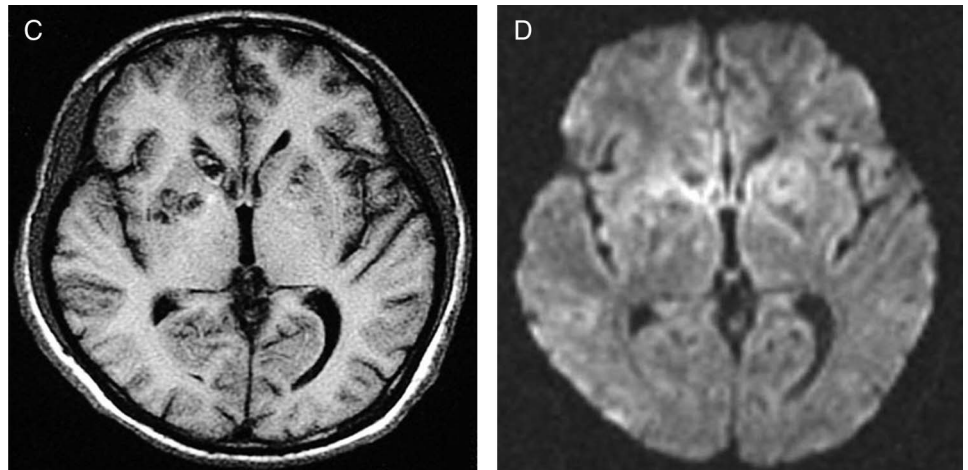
(A) Axial T2-weighted fluid-attenuated inversion recovery MRI view with significant improvement of abnormal hyperintense signals and oedema throughout. Small abnormal hyperintense signals remain in basal ganglia bilaterally, and in frontal regions and right parietal-temporal lobes. (B) Axial diffusion-weighted imaging with restricted diffusion of the cystic lesions involving both cerebral hemispheres with significant improvement. (C) Axial T1-weighted MRI view with low signals located in basal ganglia and thalamus bilaterally, and in frontal regions, and right parietal and temporal lobes, with significant improvement. (D) Axial MRI apparent diffusion coefficient (ADC) map with reduced ADC values, which confirms restricted diffusion in the significantly decreased number of cystic lesions.
